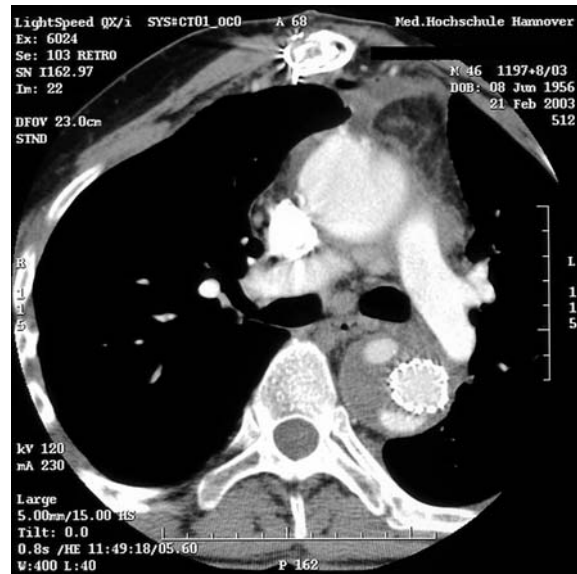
Contrast computed tomography scans of a patient with a chronic aortic dissection type A following implantation of a hybrid prosthesis. The perigraft space around the stented segment of the hybrid prosthesis in the descending aorta is thrombosed partially at 1 week postoperatively
